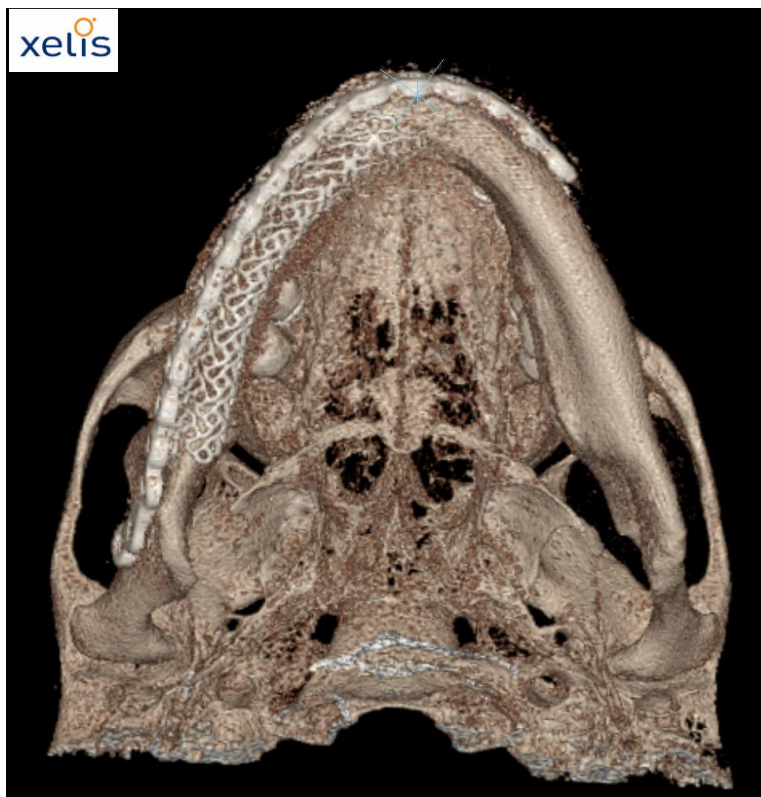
Immediate Post-Operative CT (inferior "foot" view)
